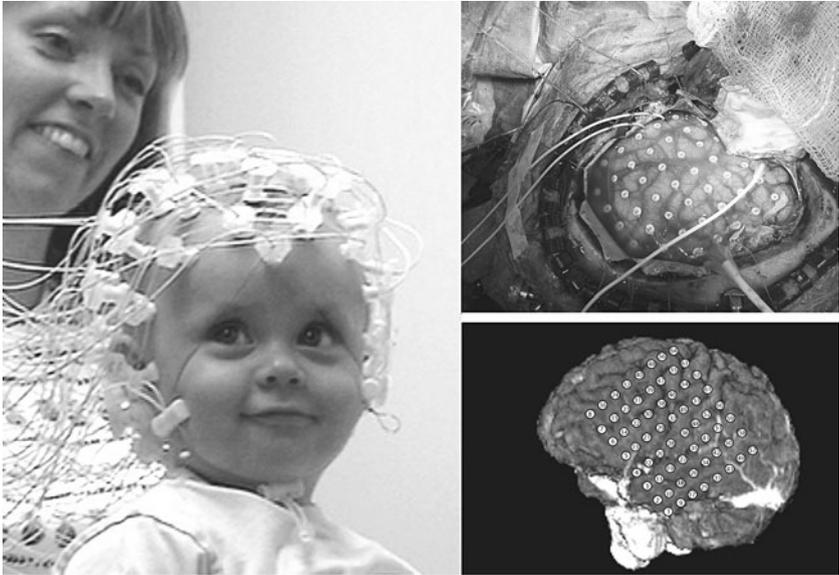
Electrical activity of the cerebral cortex can be monitored by multiple electrodes placed on the scalp (“geodesic” helmet, left). Better spatial resolution can be achieved by subdural “grid” electrodes: intraoperative placement of the subdural grid after craniotomy (top right) and the estimated electrode positions of the recording sites based on the patient’s structural MRI (magnetic resonance imaging) scan acquired after the electrodes were implanted (bottom right). Infant photo is courtesy of A. Benasich, Infancy Studies Laboratory, Rutgers University; photo of grid electrodes is courtesy of R.T. Knight and R. Canolty, University of California–Berkeley.
